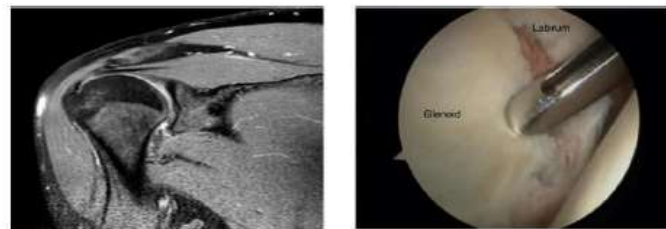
MRI showing Bankarts lesion, later confirmed on arthroscopy
